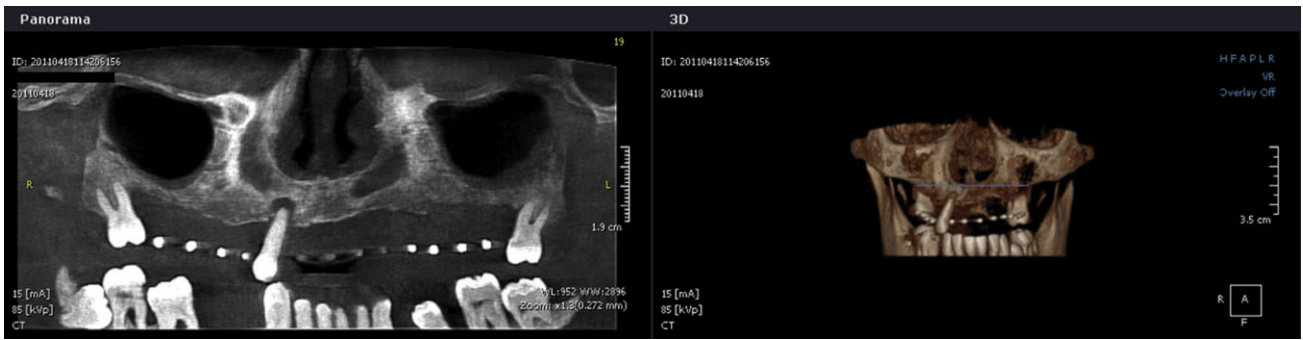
Reformatted panoramic view and reconstructed three-dimensional image from preoperative CBCT showing the radiopaque landmarks of the radiographic/surgical stent.
